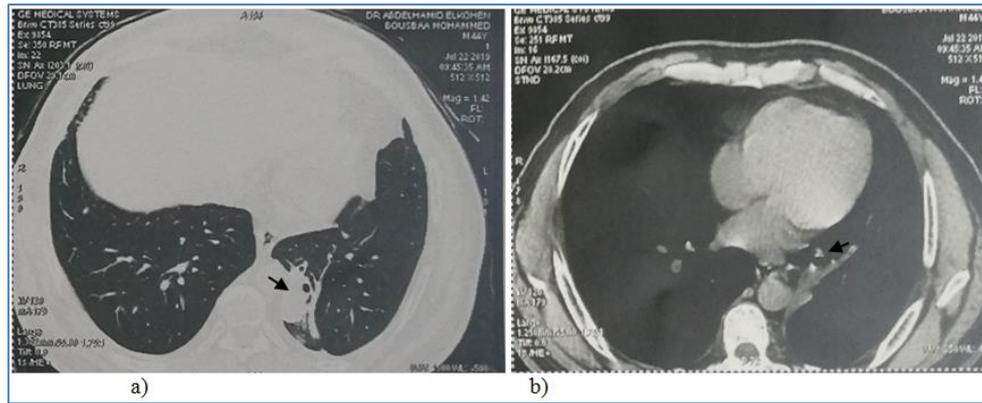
Thoracic computed tomography: a) localized left lower lobe bronchial dilatations b) appearance of atelectasis
